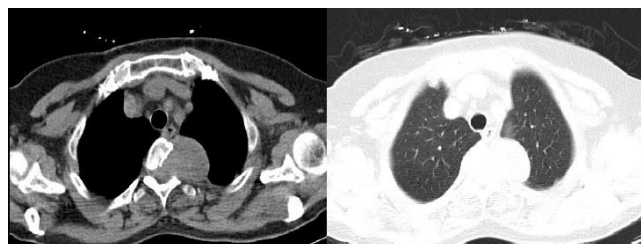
Thoracic computed tomography scans of the patient (at T4 level)
